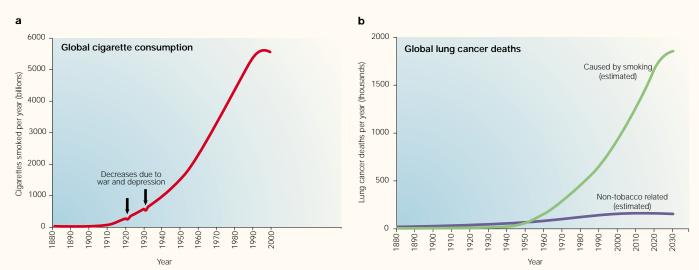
Global cigarette consumption (a) and lung cancer mortality (b), 1900–2030. Consumption peaked in the 1990s; lung cancer rates will not peak until 2020 or 2030. Consumption figures for the pre-1950 period are based on data from P. N. Lee<sup>46</sup> and estimates of United States production and global market share. Consumption is assumed to be roughly equal to production in both cases. Production (= consumption) data for 1950–1998 are from the Worldwatch Institute and the United States Department of Agriculture. Post-1950 figures are minimum values, as hand-rolled cigarettes are ignored. Pre-1990 lung cancer rates are calculated from the assumption that one lung cancer death is generated for every 3 million cigarettes smoked, with a 35-year time lag between consumption and mortality. Non-tobacco-related lung cancers are those from 'background' sources such as naturally occurring radon, occupational exposures such as asbestos, petrochemical products, inhaled radioactive gases from mining, spontaneous tumours, and tumours from X-rays or unknown causes. Post-2000 projections assume no improvements in lung cancer treatment.
